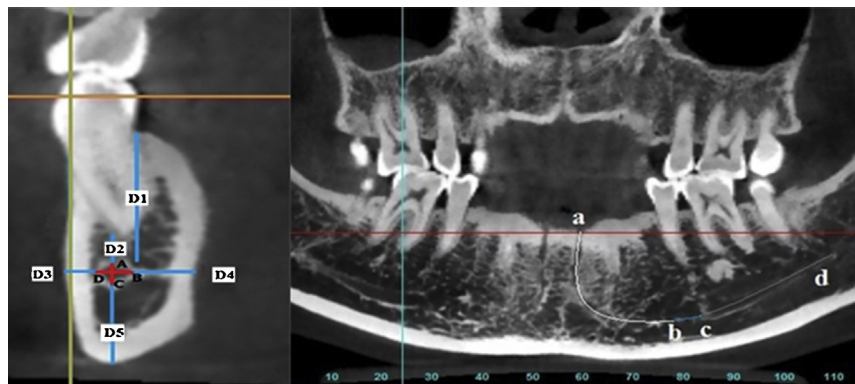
Measurements of the mandibular incisive canal (MIC) in cross-sectional view and panoramic view on CBCT: A–C, vertical diameter; B–D, horizontal diameter; D1, distance from the MIC to the alveolar crest of the mandible; D2, distance from the MIC to the apex of the tooth; D3, distance from the MIC to the buccal cortical border of the mandible; D4, distance from the MIC to the lingual cortical border of the mandible; D5, distance from the MIC to the lower margin of mandible; ab, length of the MIC (length of curve).
